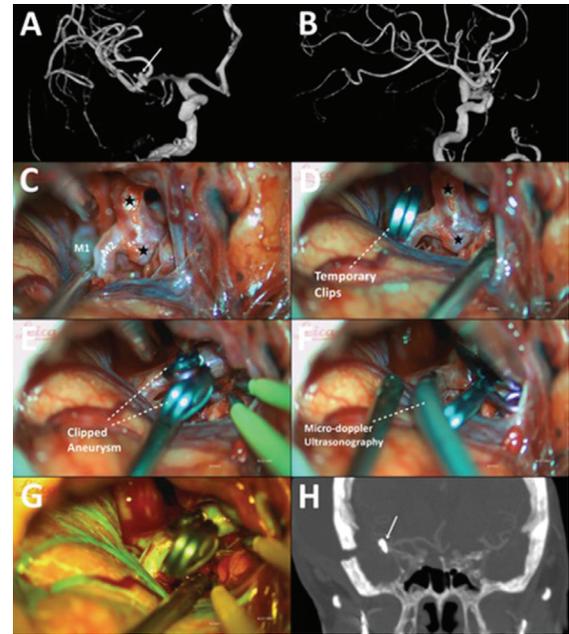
A 71-year-old female patient who underwent surgery due to an aneurysm in the hemorrhaging bifurcation of the right middle cerebral artery (MCA). A,B. Three-dimensional anterior-posterior and lateral images from preoperative digital subtraction angiography showing a saccular aneurysm (arrow) involving both trunci with a small bleb in the right MCA bifurcation, measuring 6×4 mm. C. Image of the aneurysm dome (star) and the right MCA M1 and M2 segments. D. Image of the temporary clip placed on the aneurysm dome and right MCA M1 segment. E. Image of the aneurysm dome being closed with two permanent clips. F. Image of the flow in the aneurysm dome and right MCA branches being explored by micro-Doppler ultrasonography. G. Videoangiography mode image after sodium fluorescein injection showing that the aneurysm dome is not filled. H. Postoperative computed tomography brain angiography image, coronal section, showing the aneurysm clip (arrow), no residual aneurysmal embolization, and no parent artery loss
